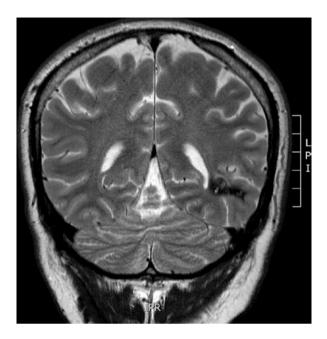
Coronal cranial MRI, T2 sequence, showing the same cavernoma
